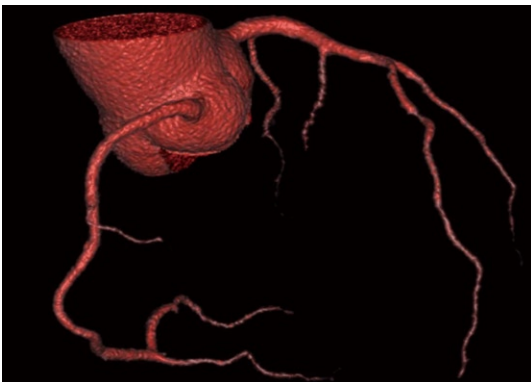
Three-dimensional volume rendering of the coronary arteries and side branches are clearly visualized with use of 320-slice computed tomography angiography in a 58-year-old man presenting with chest pain. Volumetric data were acquired within a single heartbeat with excellent image quality.
